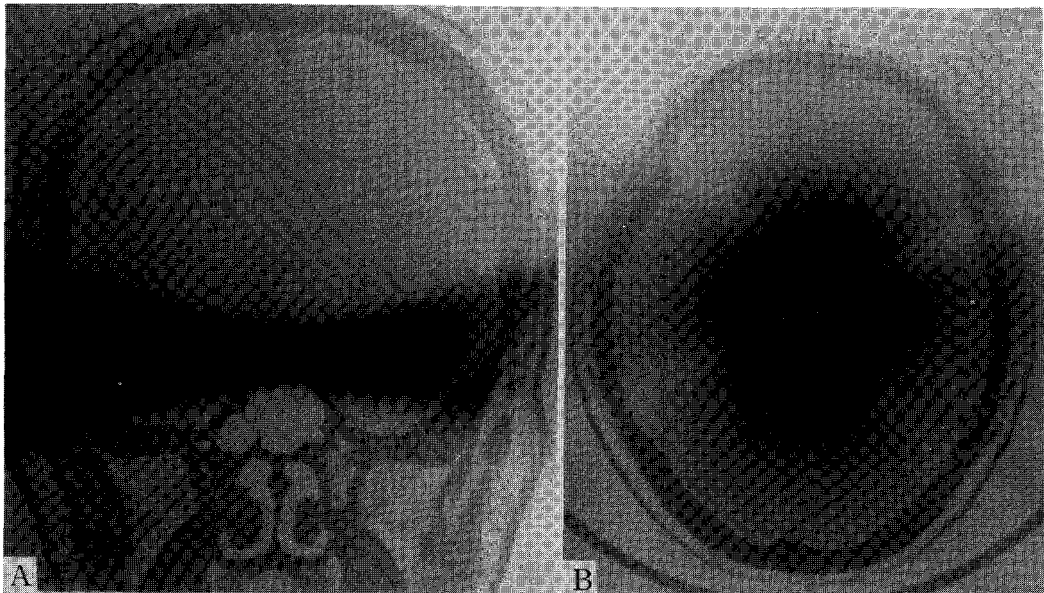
Dose distribution in the three dimensional planes obtained with multiple arcs of  $1 \times 1$  square centimeter field at the isocenter of a 6 MV X-ray beam. A) coronal plane, B) transverse plane.
